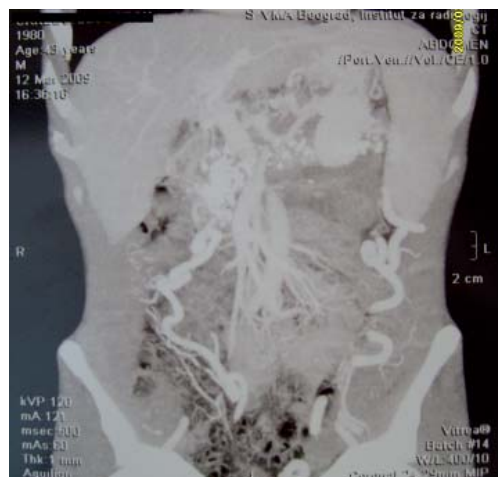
Pseudocyst and the enlarged spleen with calcification through the head, body and tail of the pancreas on multislice computed tomography (MSCT) angiography
